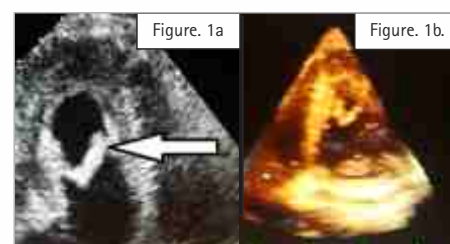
Echocardiography showing concentric hypertrophy of left Ventricle with apical prominence and band like structure meeting in mid cavity forming A "V-shape configuration (arrow).
